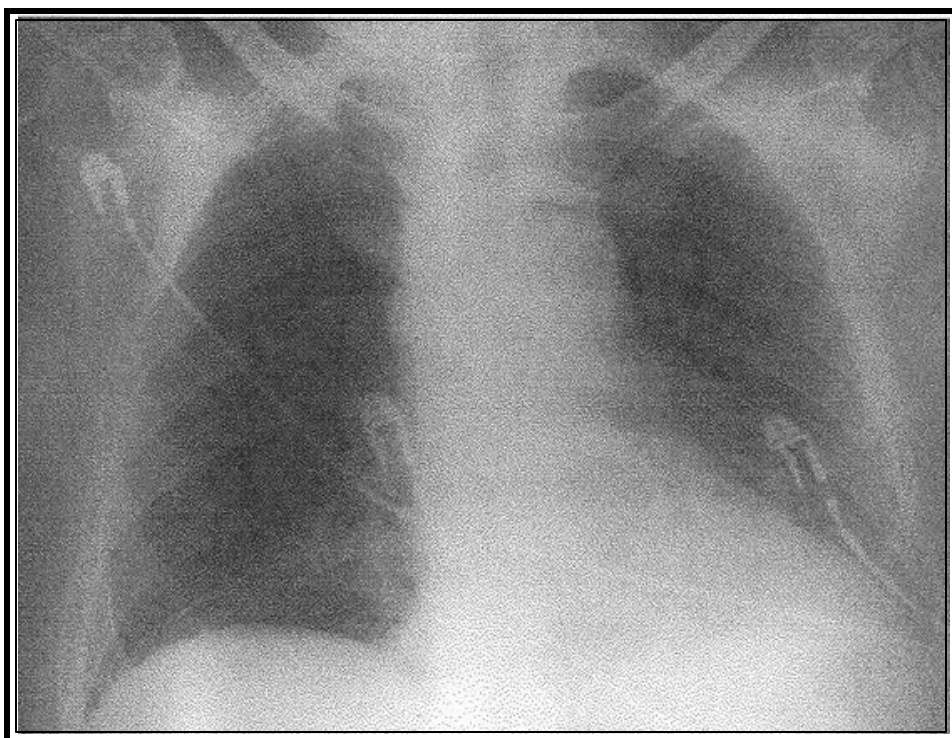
Chest X-ray of inhalational anthrax patient showing prominent superior mediastinum and possible small left pleural effusion.⁶
